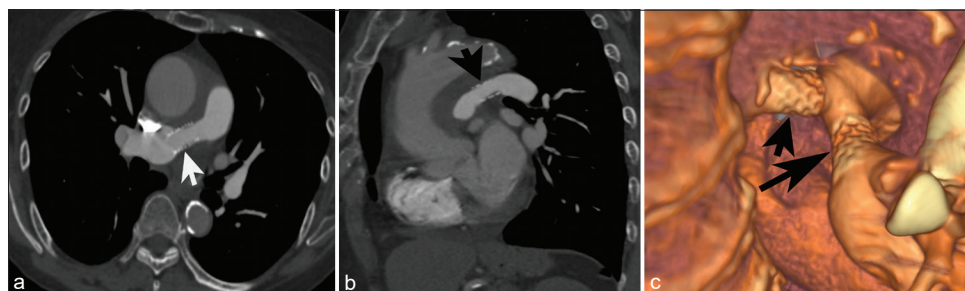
A 76-year-old female with a history of takayasu arteritis of the pulmonary arteries has follow-up imaging with axial computed tomography (CT) angiogram 8 years following right pulmonary artery stent placement. (a) widely patent right pulmonary artery (white arrow); (b) sagittal oblique CT angiogram with widely patent left pulmonary artery (black arrow); (c) 3D CT angiogram image from posterior oblique perspective showing widely patent left (short black arrow) and right (long black arrow) pulmonary arteries.
